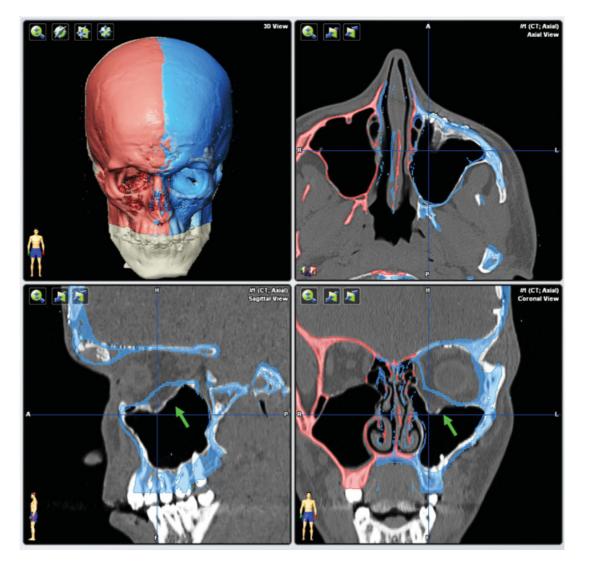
Posttraumatic secondary reconstruction of the left orbit: preoperative planning. The unaffected right side (red) is reflected onto the affected left side (blue), creating a virtual template for reconstruction of the left orbit. The orbital floor fracture is marked with a green arrow. Abbreviation: CT, computed tomography.
